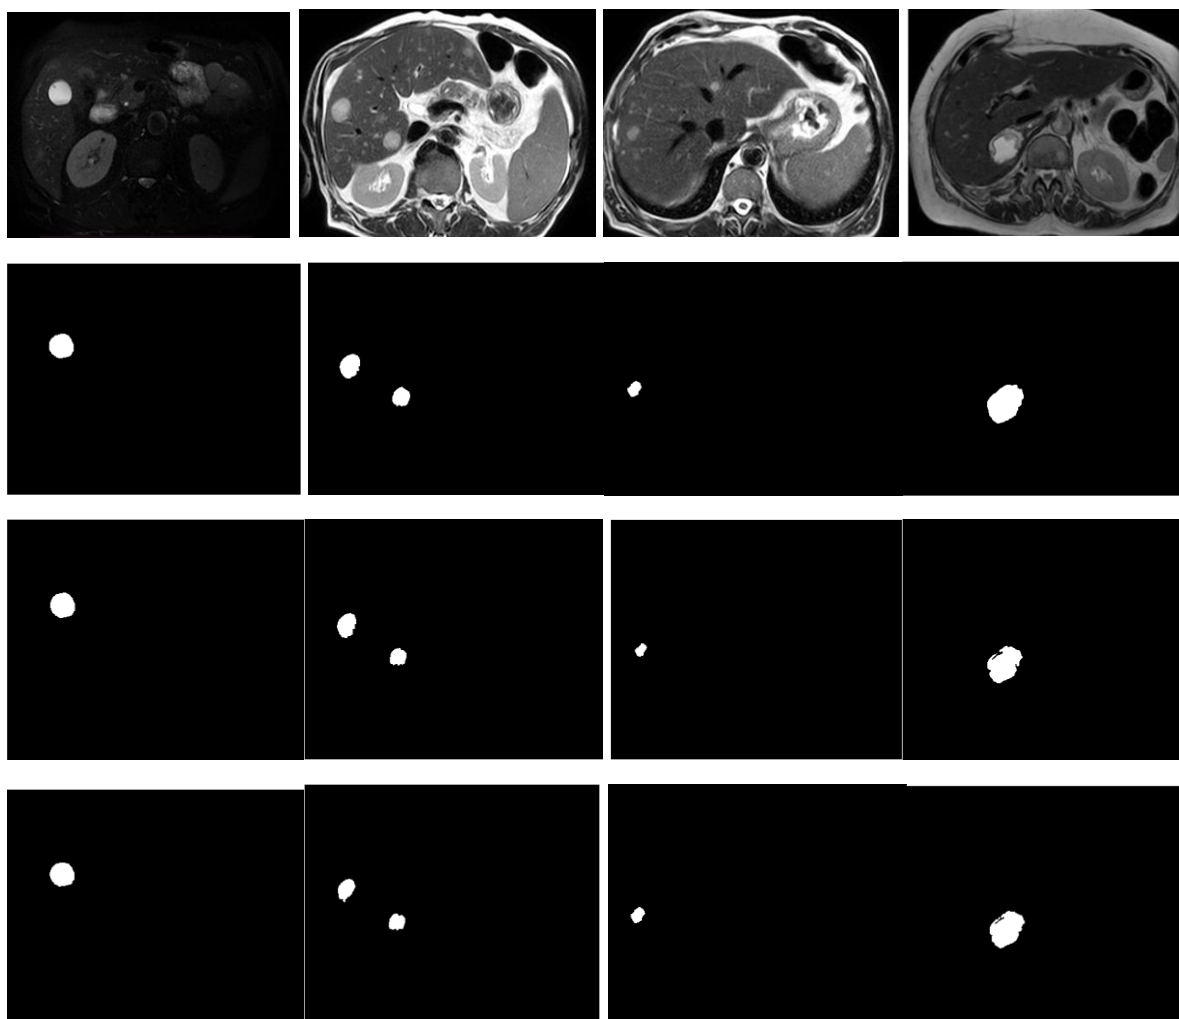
The refined extracting abnormal regions of Im11, Im22, Im33 and Im44 CT scan images with four, five and six nodes from the first line of images to the last one (in the current study).
